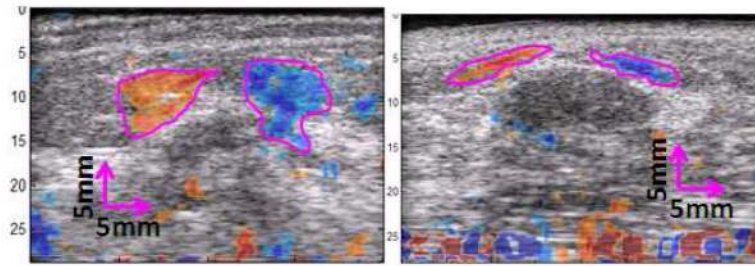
Examples showing the images of ASSE as a color-overlay on corresponding sonograms of a (left) cancer and (right) fibroadenoma. The observer's outlines (magenta lines) of the axial-shear strain areas of interest are also shown.
